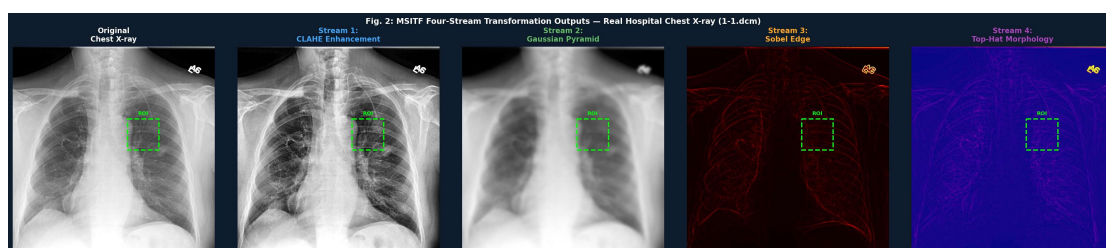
MSITF four-stream transformation outputs on real clinical chest X-ray (Basavatarakam Cancer Hospital, DICOM: 1-1.dcm). From left: Original X-ray, Stream 1 (CLAHE), Stream 2 (Gaussian Pyramid), Stream 3 (Sobel Edge), Stream 4 (Top-Hat Morphology). Green dashed ROI box indicates region of interest analysed for nodule detection.
